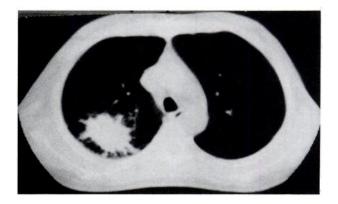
Chest CT scan on admission showing a round mass with irregular borders in the right upper lobe.
